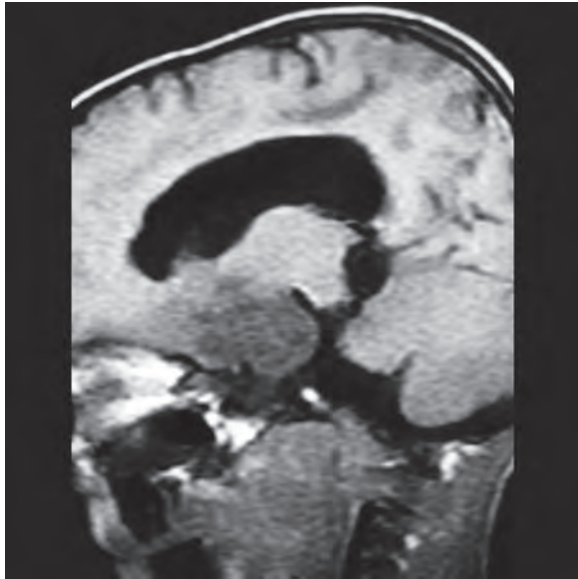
MRI of the brain sagittal section showing hypointense lesion involving the hypothalamus
